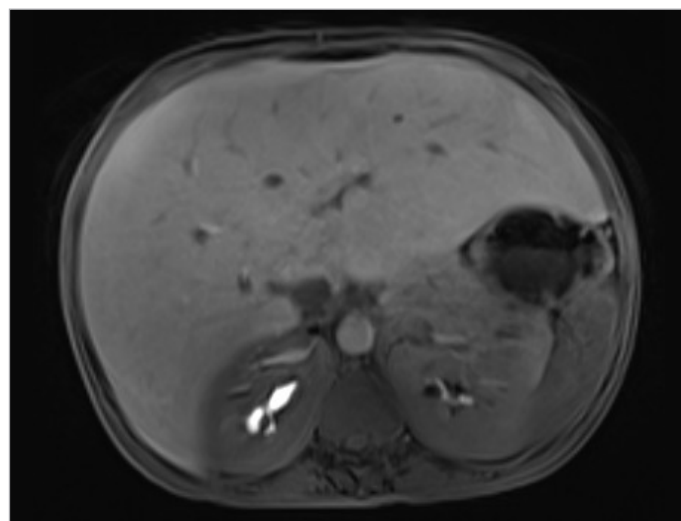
MRI of liver: evidence of hepatomegaly with steatosis. No discrete hepatic lesions.
